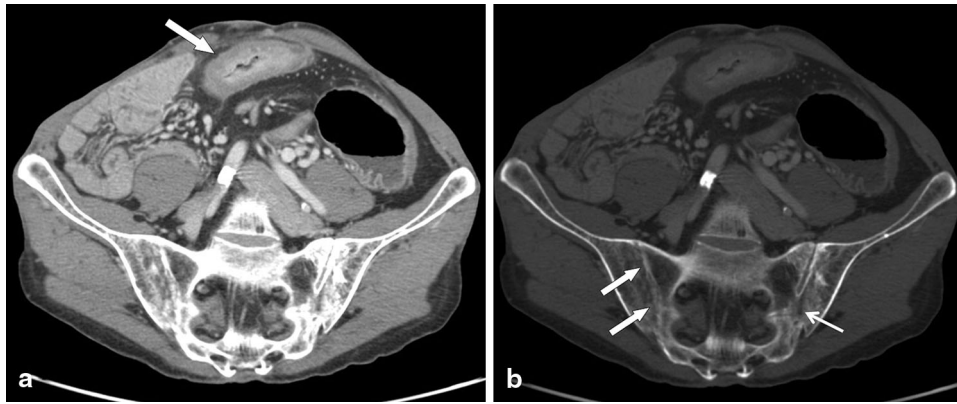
a, b 52-year-old man with Crohn's disease and sacroiliitis. a Axial CT enterography image shows thickening and mural stratification with mucosal hyper-enhancement of an ileal loop affected by Crohn's disease (*arrow* in a). b The same axial CT
